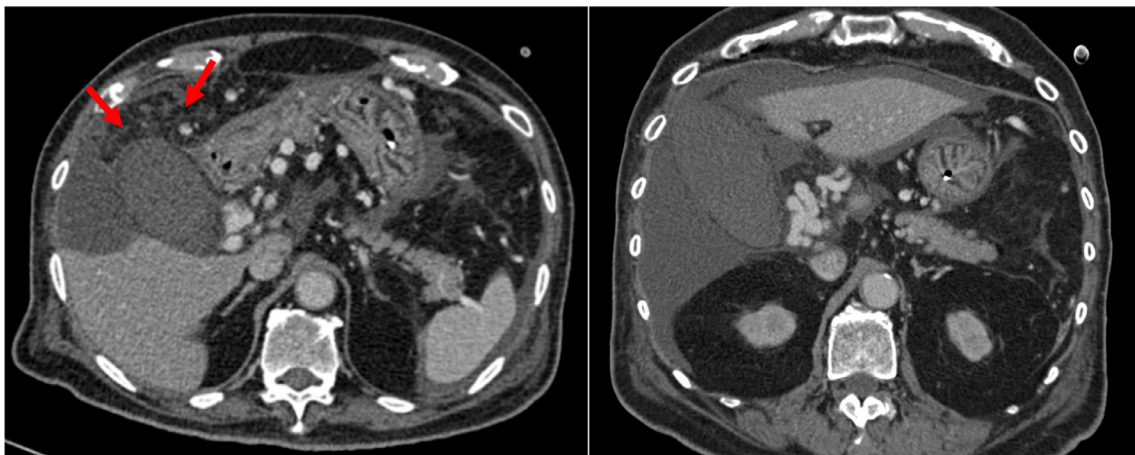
Axial CT scan through the gallbladder in the portal venous phase (A). Oblique axial reconstruction CT scan along the longitudinal axis of the gallbladder in the portal venous phase (B). Gallbladder distension (with a transverse diameter of 5 cm), diffuse gallbladder wall thickening (with a thickness of 5 mm), absence of wall enhancement, pericholecystic fat stranding (→) without the presence of gallbladder calculus. No varicose vein in the gallbladder wall.
